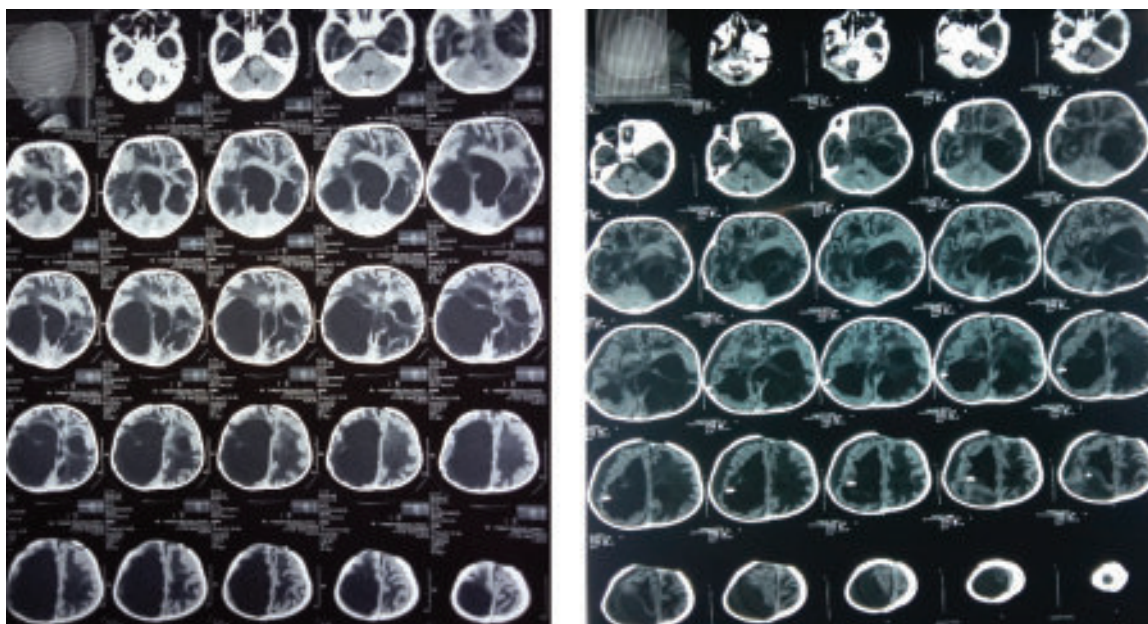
(a) CT scan of head before shunt showing both lateral ventricles and 3rd ventricle are dilated. There are multiple septations present within the lateral ventricles. (b) CT scan of head after right sided VP shunt showing lateral ventricles and 3rd ventricular size has decreased than previous and there is also right sided subdural hygroma.
